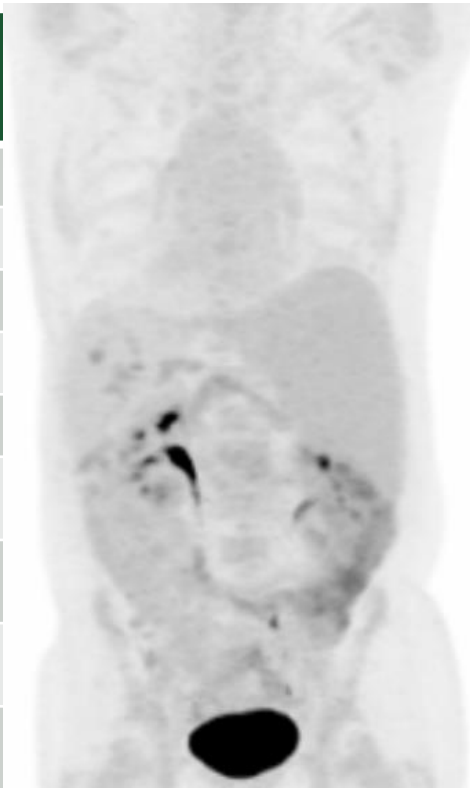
PET/CT performed 2 weeks after completion of Obinutuzumab course demonstrating absence of FDG-avid disease.
